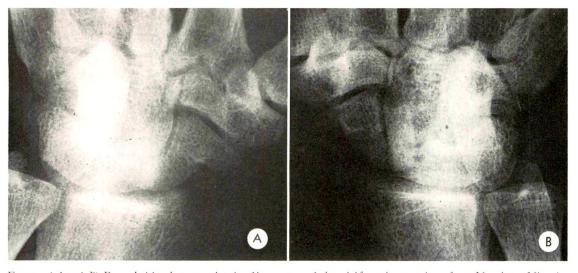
(A and B) Bony bridge between hook of hamate and the pisiform in a patient from Northern Nigeria. In addition bilateral lunato-triquetral fusion is present. (Poor quality of the roentgenograms attributable to field conditions.)
